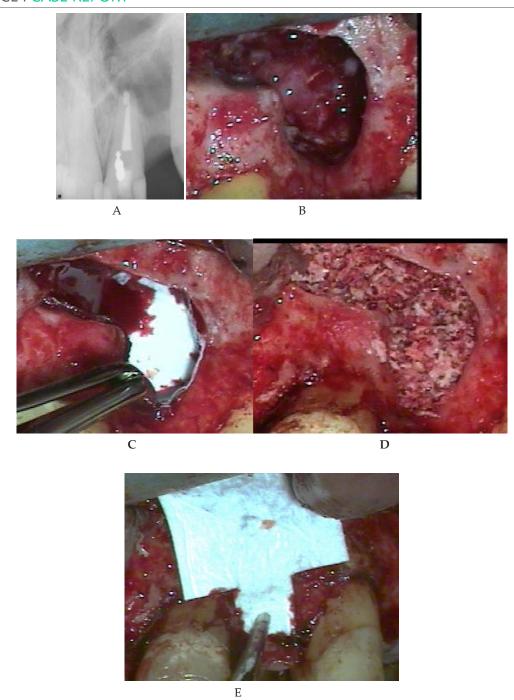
Clinical and radiographic pictures of apical surgery of maxillary left central incisor during apical surgery. (A) Osteotomy window after enlargement following flab reflection.(B) Periapical radiograph was taken following resection, retro-prep and retro-fill to verify the angle of resection, adequate depth of retro-prep and adequate condensation of retro-fill. (C) Resorbable collagen membrane was placed at the palatal depth of the defect. (D) 2 CC of allograft bone was packed against the membrane. (E) Resorbable collagen membrane was placed at the buccal aspect of the defect and sutured to periosteum.
